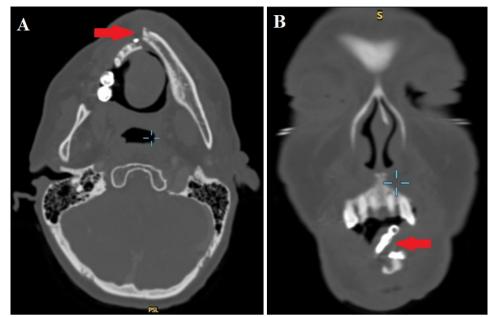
CT scan findings. (A) Axial view of CT showing pathological fracture of symphysis of mandible (indicated by red arrow). (B) Coronal view showing fracture of titanium plate (indicated by red arrow).
